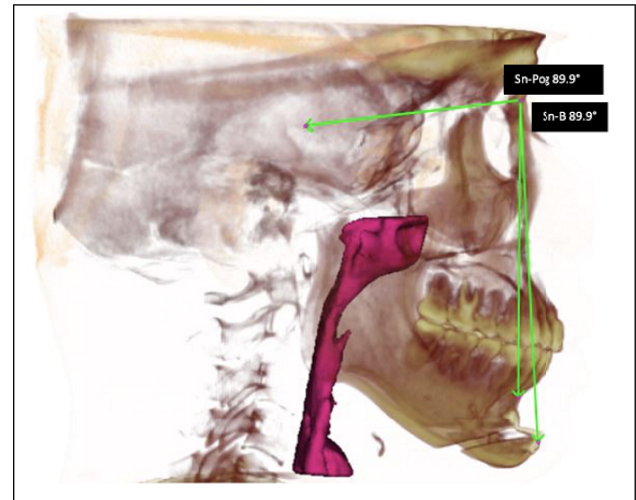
Cone-beam computed tomography that shows study measurements: airway volumetry, sella-nasion B point (Sn-B), sella-nasion-pogonion (Sn-Pog) and mandibular occlusal plane angles, and hyoid bone, B point and pogonion 3-dimensional spatial position.
